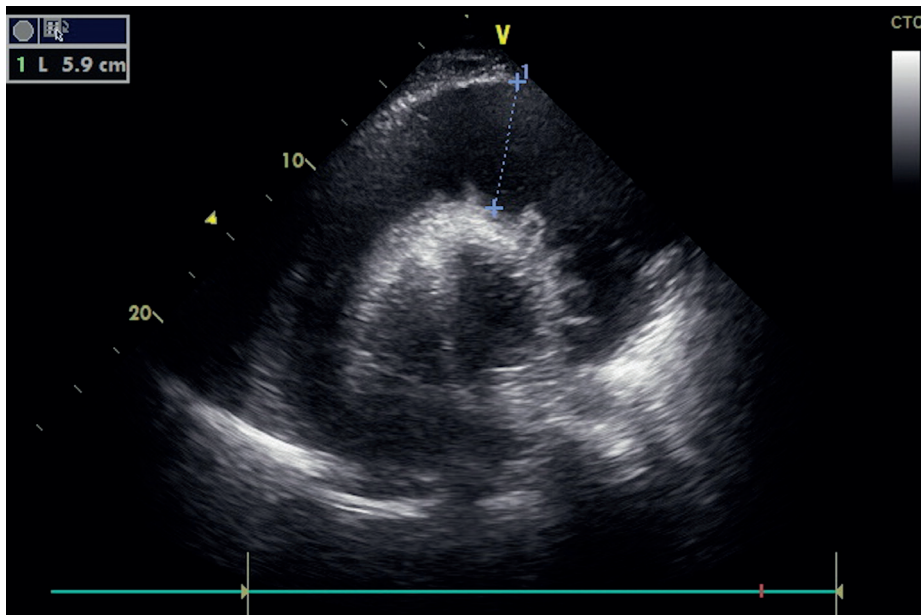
Transthoracic echocardiography, apical four-chamber view showing a large pericardial effusion of 5.9 cm.
